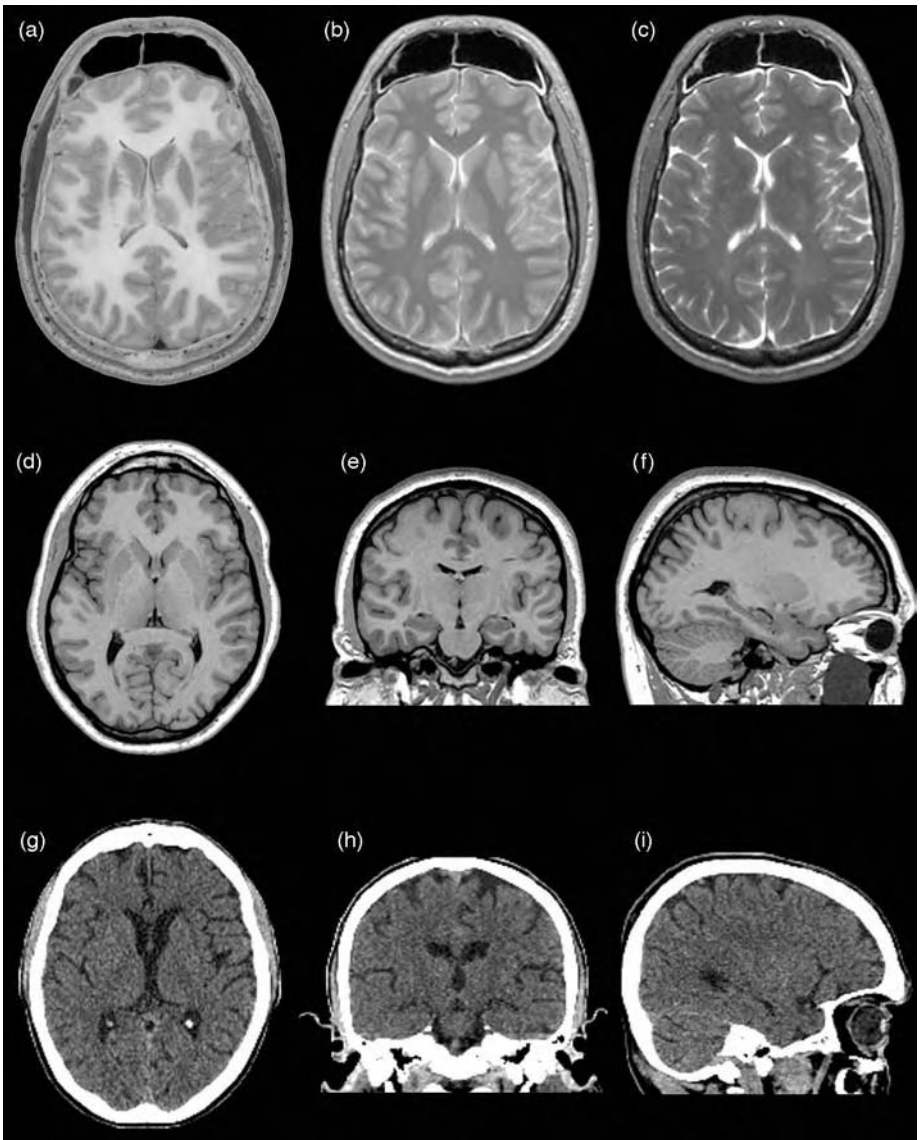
The top left axial cut (a) was performed at post-mortem, to compare to the pre-mortem imaging done at precisely the same level in (b) (a mixed weighted image) and (c) (a T2 weighted image). From a different individual, the middle row are all T1 weighted images in different planes: axial (d), coronal (e); and sagittal (f); Also, from a different individual, the bottom row depicts axial (g), coronal (h); and sagittal (i) images from CT scans. Note the differences in tissue differentiation between MRI and CT imaging, but that both provide good approximation of the actual brain as shown in (a). (A colour version of this figure is given in the Plate section.)
